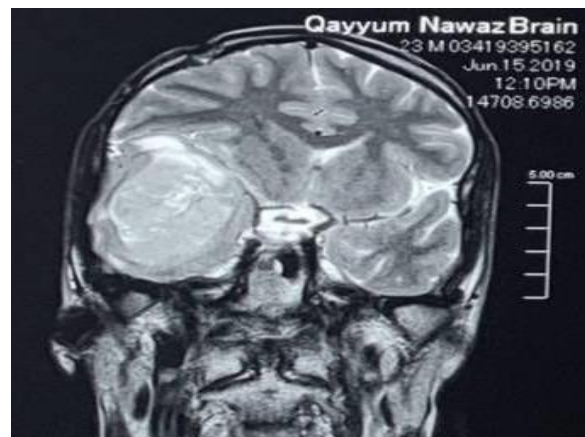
MRI T2-Weighted image showing extra-axial mixed density lesion in right temporal lobe with mass effect.
